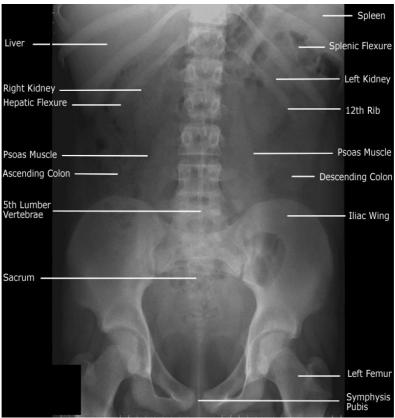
Plain radiograph of the abdomen in anteroposterior view.
